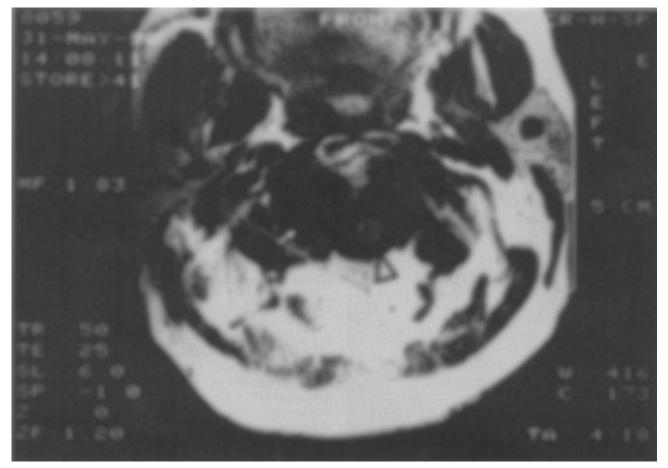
T1 weighted axial magnetic resonance image. Right-sided destruction of the lateral parts of the second and third cervical vertebra is apparent. The low-signal area (arrow) in place of the destructive lesion is compatible with an amyloid deposit (Δ marks spinal channel with myelon).
